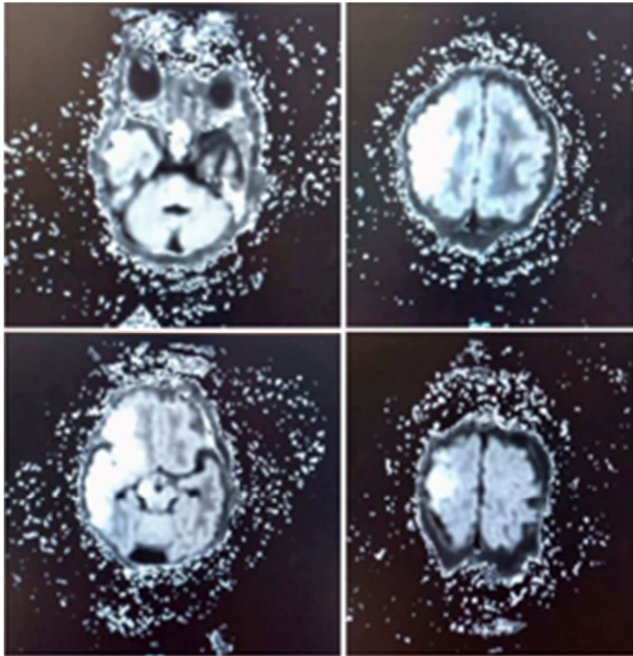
MRI brain showing large right sylvian ischemic stroke.
